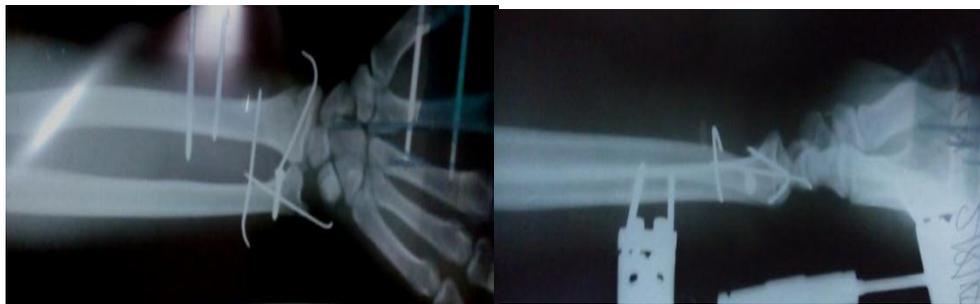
Post-operative radiographs after reduction and fixation of the ulnar fracture and the radius fracture was stabilized with external fixation.
